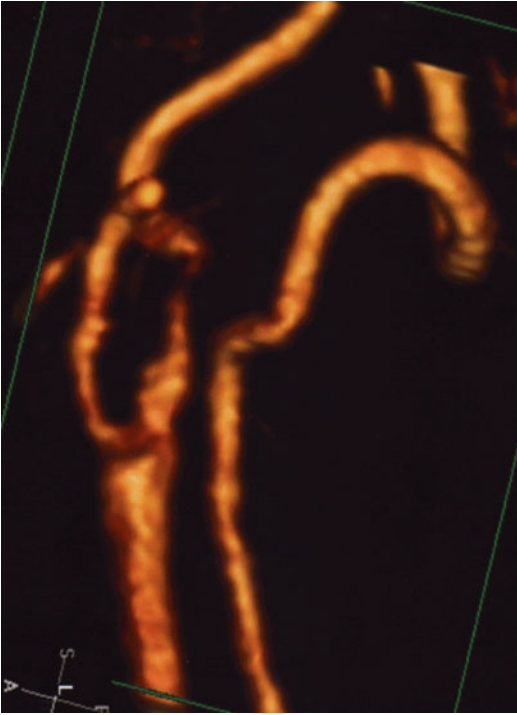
Critical ICA stenosis seen on CT angio prior to successful stenting
